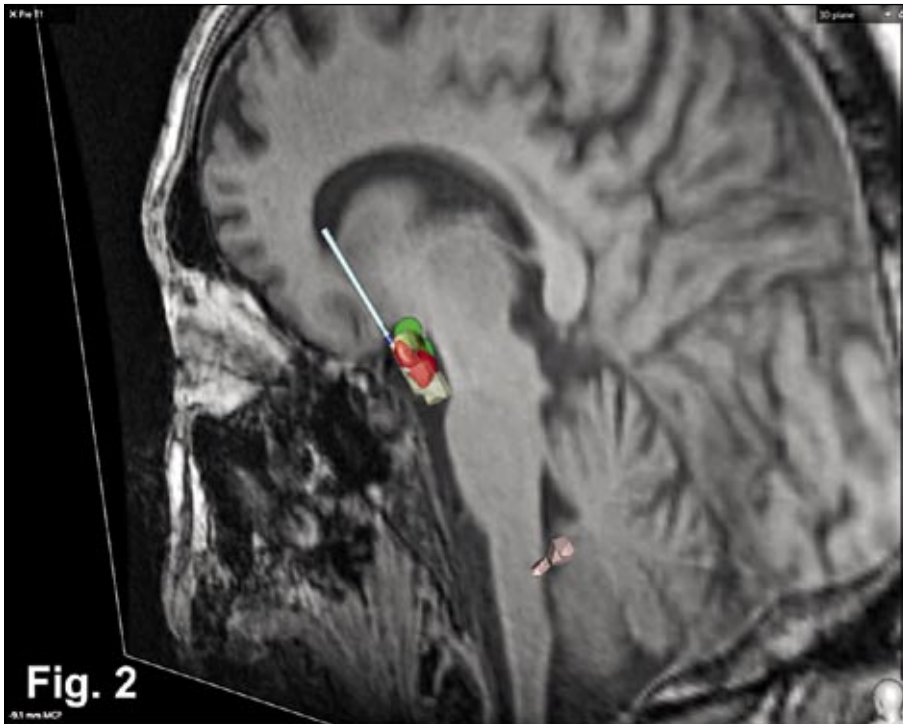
Deep brain stimulation may induce ataxia in patients with tremor as a side effect. We could demonstrate that stimulation sites for tremor suppression (green) and those inducing ataxia (red) are closely related, but non-overlapping. Stimulation of ataxia-inducing areas leads to antidromic activation of the cerebellar vermis as shown by FDG-PET. These findings may help to define optimized target areas for deep brain stimulation.
